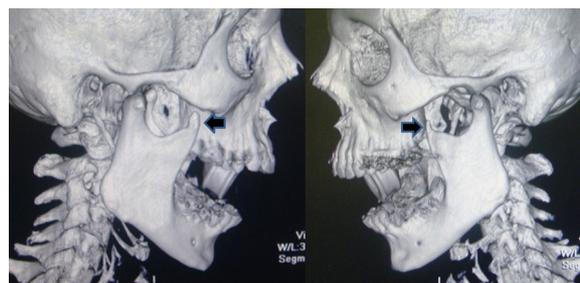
Three-dimensional computed tomography showing a hook-shaped bony process at the top of the coronoid, mainly to the left, which was thought to have been formed by something radiologically “invisible” such as a fibrotic band.
